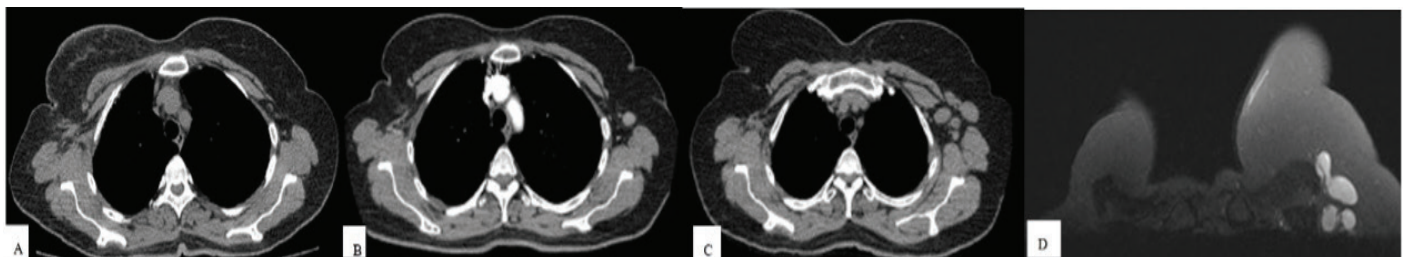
A) In a patient with a history of right partial mastectomy, no pathological lymph node was observed in the left axilla on the pre-COVID-19 vaccine thoracic CT scan (2020). B) In the post-vaccine thoracic CT scan (2022), a lymph node with cortical thickening was detected. FNAB was performed, and the result was benign. C) In 2023, an increase in the size of the lymph nodes was observed. D) In 2023, MRI was performed on the same patient. Due to the progression of lymphadenopathy, a tru-cut biopsy was performed, and the result was reported as benign
